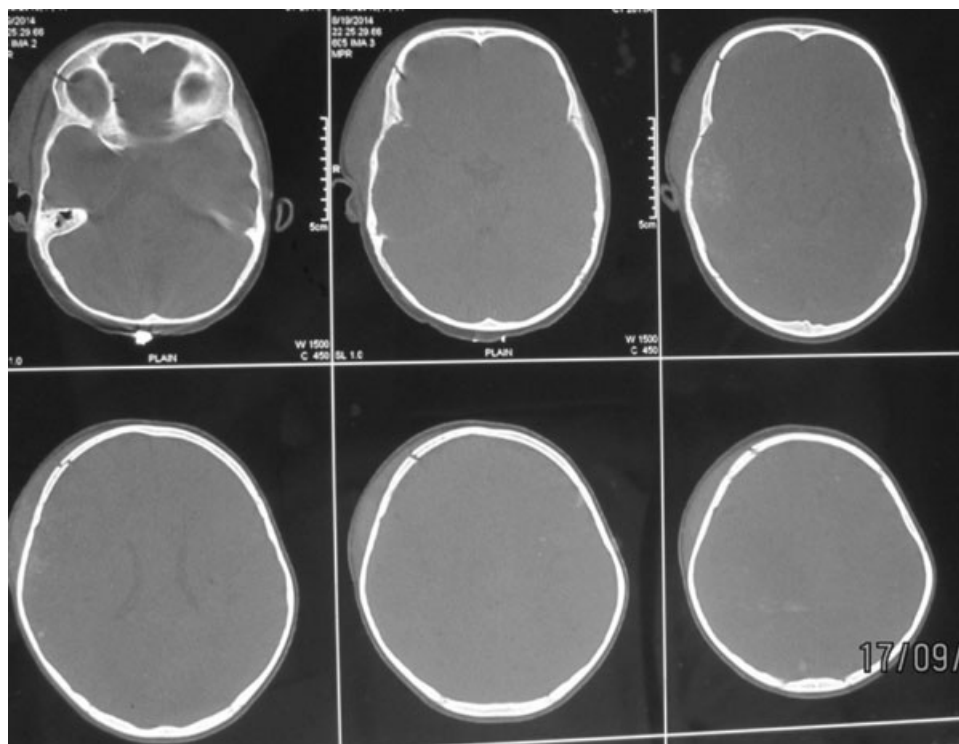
CT brain plain (bone window) showing the fracture. CT, computed tomography.
